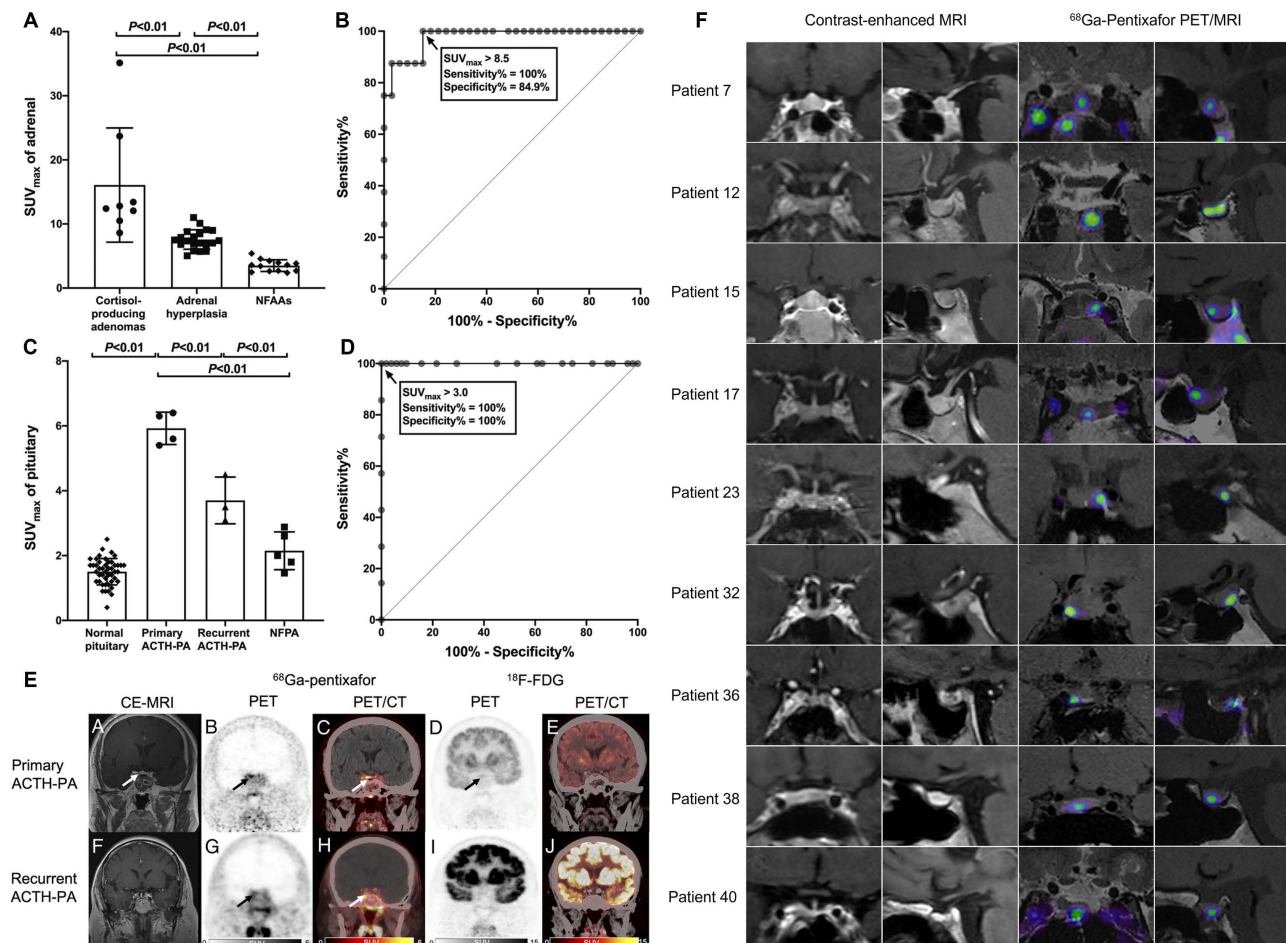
Clinical application of [⁶⁸Ga]Pentixafor in CS. (A) SUV_{max} comparison of [⁶⁸Ga]Pentixafor in cortisol-producing adenoma, adrenal hyperplasia, and nonfunctioning adrenal adenoma. (B) ROC analysis of [⁶⁸Ga]Pentixafor SUV_{max} for discriminating cortisol-producing adenoma from adrenal hyperplasia and nonfunctioning adrenal adenoma. (C) SUV_{max} distribution of [⁶⁸Ga]Pentixafor across normal pituitary, primary/recurrent ACTH-producing pituitary adenoma, and nonfunctioning pituitary adenoma. (D) ROC evaluation of [⁶⁸Ga]Pentixafor SUV_{max} for differentiating ACTH-producing pituitary adenoma from nonfunctioning pituitary adenoma and normal pituitary. (E) A 41-year-old man with Cushing's disease, pathologically confirmed as a right-sided ACTH-producing pituitary adenoma (5 mm maximum diameter). Contrast-enhanced MRI demonstrated a hypointense microadenoma in the right pituitary wing (arrow). [⁶⁸Ga]Pentixafor PET/CT coronal PET and fusion images revealed focal uptake (SUV_{max} 6.3; arrows), while [¹⁸F]FDG PET/CT showed only mild diffuse pituitary uptake without distinct foci (arrows). A 41-year-old woman with recurrent right-sided ACTH-producing pituitary adenoma (3 mm maximum diameter). Contrast-enhanced MRI was negative. [⁶⁸Ga]Pentixafor coronal PET and fusion images demonstrated increased uptake (SUV_{max} 4.5; arrows), whereas [¹⁸F]FDG coronal PET and fusion images showed no abnormal uptake in the pituitary fossa. Adapted with permission from [81], copyright © 2022, Wolters Kluwer. (F) Coronal and sagittal contrast-enhanced MRI and corresponding [⁶⁸Ga]Pentixafor PET/MRI scans in study participants show examples of negative cases (no detected lesion). Adapted with permission from [105], copyright © 2024, Radiological Society of North America.
